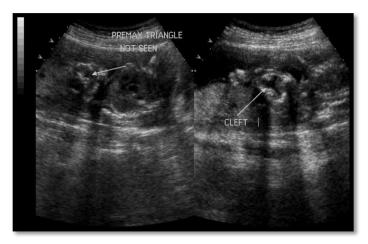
A 2 – D ultrasonography of the fetal face showing cleft lip. (Ansari, 2011)
